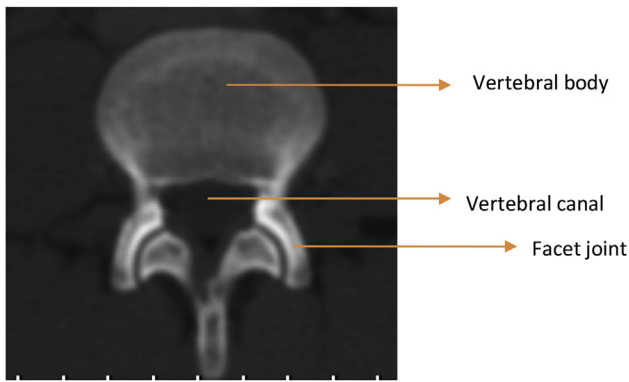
Normal facet joint on CT imaging.
